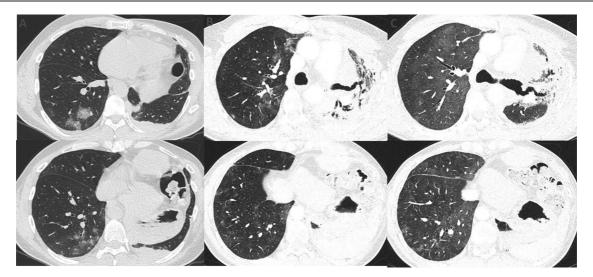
CT axial slices during the evolution of the case. (A first column) CT image from the first diagnosis of SARS-CoV-2 infection 8 months before showing ground glass opacities in the right lower lobe. (B middle column) CT image two months later, before the chemotherapy started, showing ground glass opacities in distinct lung fields. (C third column) CT image revealing persistent ground glass opacities with greater extension on patient's presentation to emergency care.
